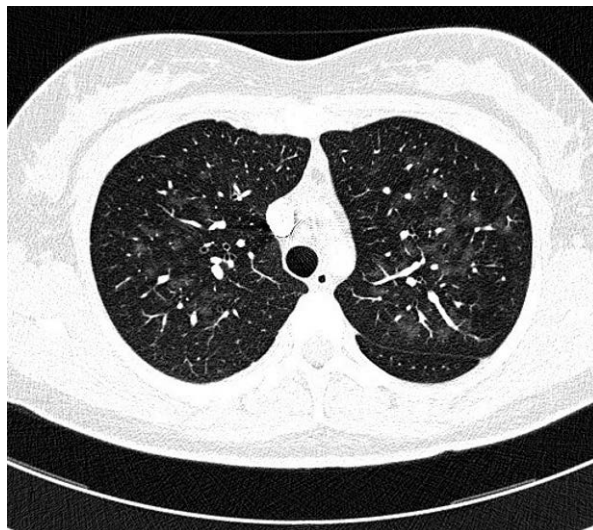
Centrilobular nodules in high resolution computed tomography of the lung of 31-years old female patient with idiopathic pulmonary arterial hypertension
